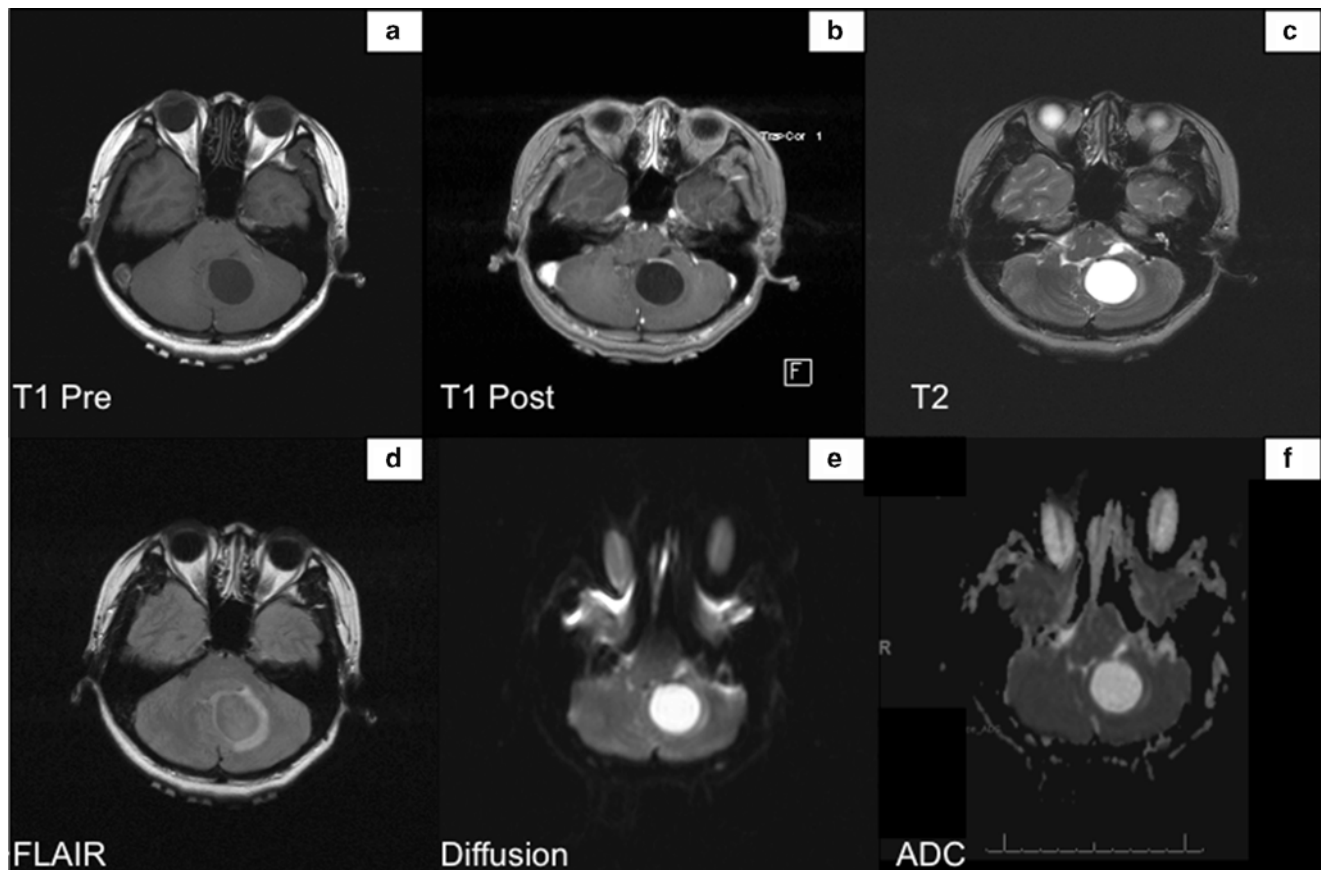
MRI shows the tumor within the inferior medial left cerebellum. Lesion is isointense with the adjacent brain parenchyma on the T1 weighted sequences (Panel a), hyperintense on T2
